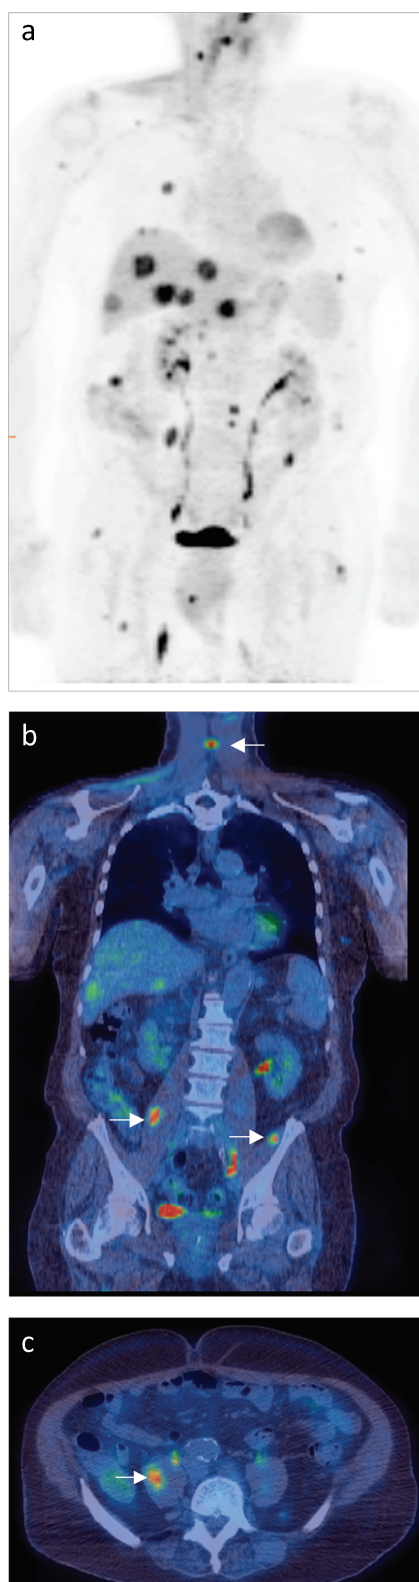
Melanoma: (a) Coronal views of ^{18}F -FDG PET/CT show multiple metastases in lymph nodes, lungs, skeleton and liver. (b) Coronal and axial fused PET/CT images also localise abnormal uptake in various muscles (arrows).
